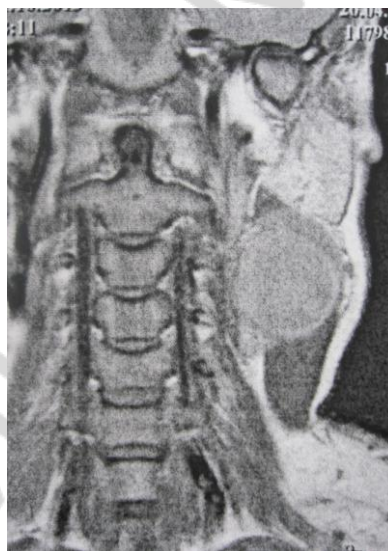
A lateral cyst of the neck on the left on NMR-CT
